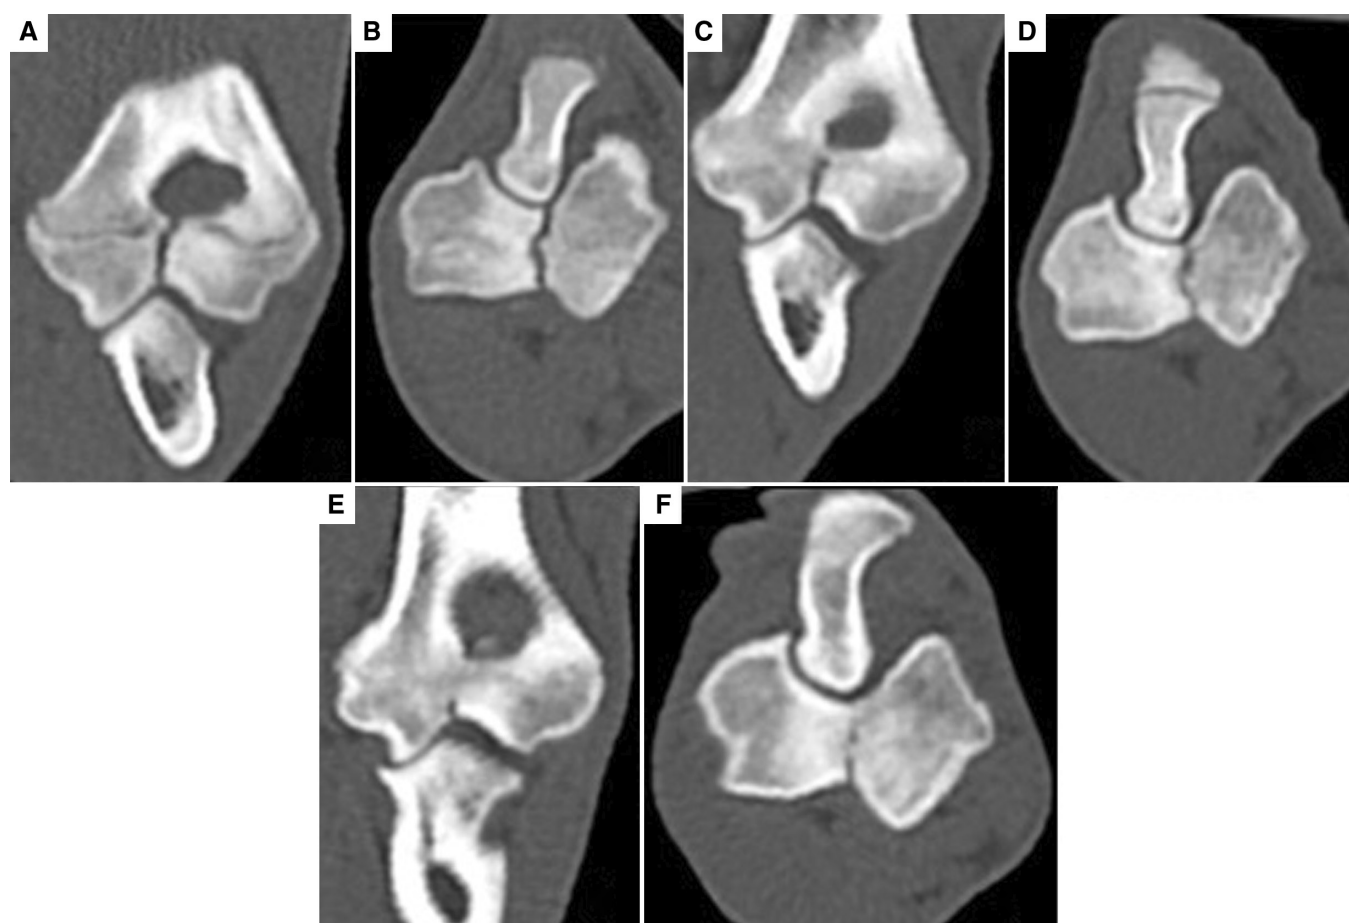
Dorsal (A) and transverse (B) computed tomography reconstructions of the elbow with a complete HIF of patient #8, whose HIF had not completely fused at follow-up. Dorsal (C) and transverse (D) computed tomography reconstructions at follow-up 4 weeks later revealing 21% fusion and at follow-up 8 weeks later, demonstrating 52% fusion (dorsal E and transverse F).
